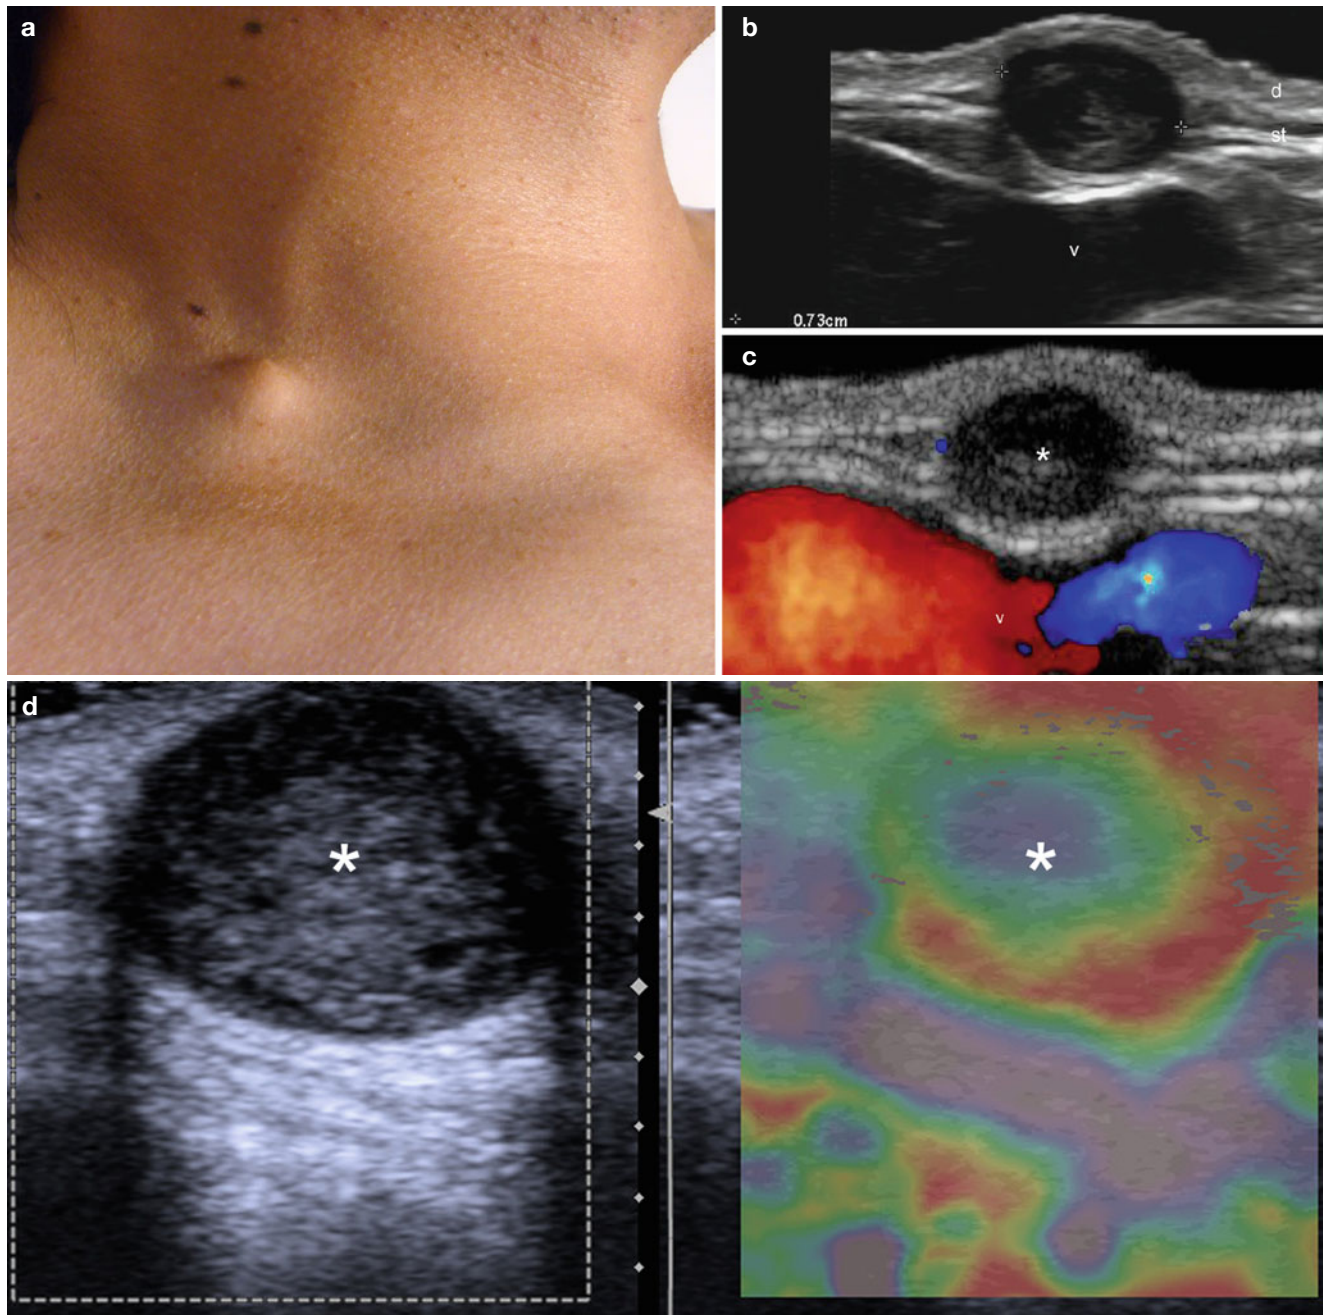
(a–e) Intact epidermal cyst. (a) Clinical image shows a skin-colored bump in the right supraclavicular region. (b) Grey scale ultrasound image (transverse view) demonstrates 0.73 cm well-defined round-shaped anechoic structure in the dermis and subcutaneous tissue. The subclavian vein (*v*) runs deep into the cyst. (c) Color Doppler ultrasound image (transverse view) shows the avascular nature of the cyst
